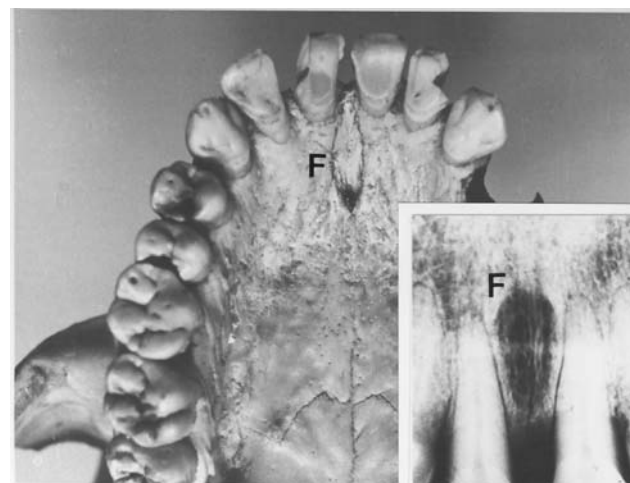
Incisive fossa (F) on a dry skull. Inset: radiograph of an incisive fossa (F) on a different dry skull. (Courtesy of Dr R. Chamda.)
